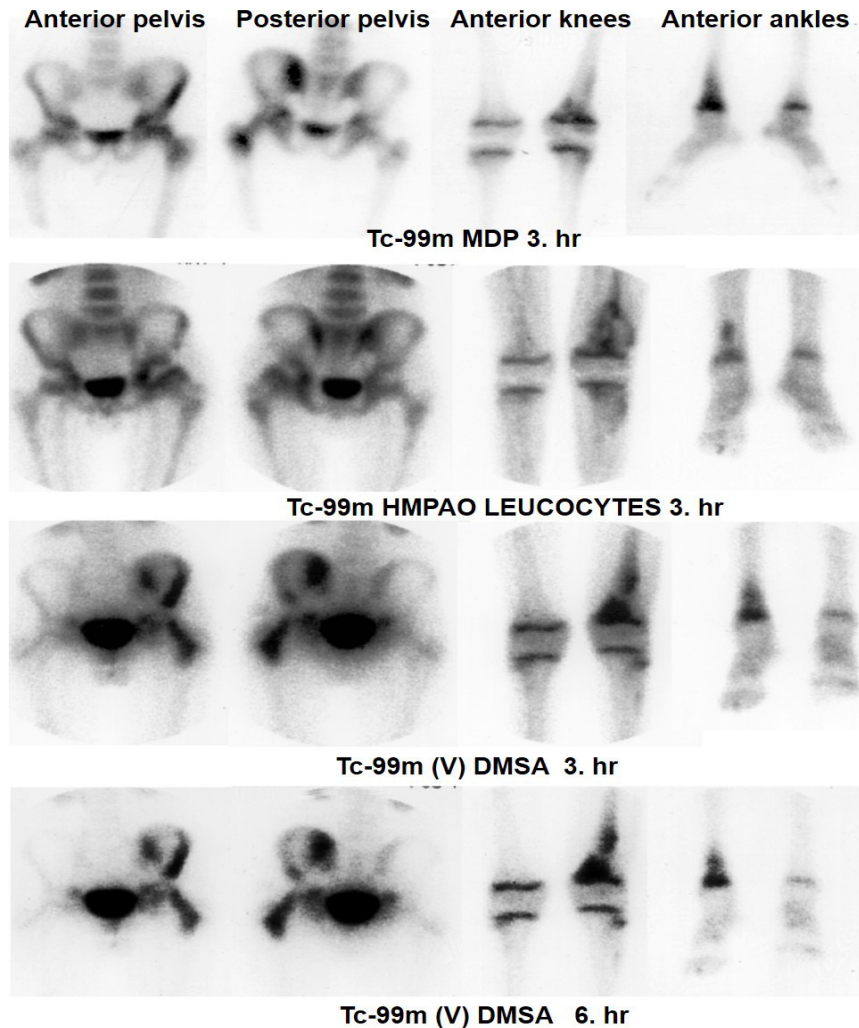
Bone scintigraphy, leukocyte scan and Tc-99m (V) DMSA scan were obtained using 370 MBq (10mCi) Tc-99m MDP, 185 MBq (5 mCi) Tc-99m HMPAO leucocytes and 185 MBq (5 mCi) Tc-99m (V) DMSA [14]; respectively. All of scintigraphy studies were acquired by LEAP collimator in 256 x 256 matrix size. Planar images were obtained at 3th hour for Tc-99m MDP and Tc-99m HMPAO leucocytes. Tc-99m (V) DMSA scans were performed at 3th and 6th hours. The period between scans of each radiopharmaceutical was two days. Uptake areas of Tc-99m HMPAO leucocytes in bone tissue were similar to bone scan and Tc-99m (V)-DMSA scan. Tc-99m (V) DMSA accumulation in the late (6.hr) was similar localizations to Tc-99m MDP uptakes. Tc-99m (V) DMSA uptake in early phase (3.hr) scan and late phase (6.hr) scan were observed in the all infected localizations of soft tissue and bone detected by Tc-99m HMPAO leucocyte scan
